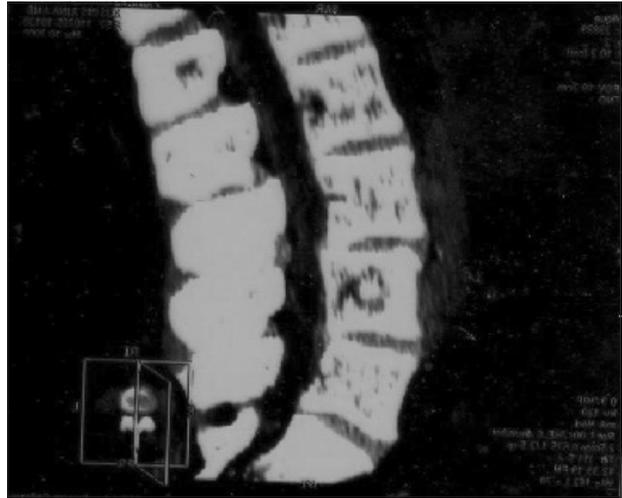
CT of the lumbar region revealing spondylosis segments L3-S1, L4 disc dorsal median protrusion, L5 disc slight paramedian protrusion.
